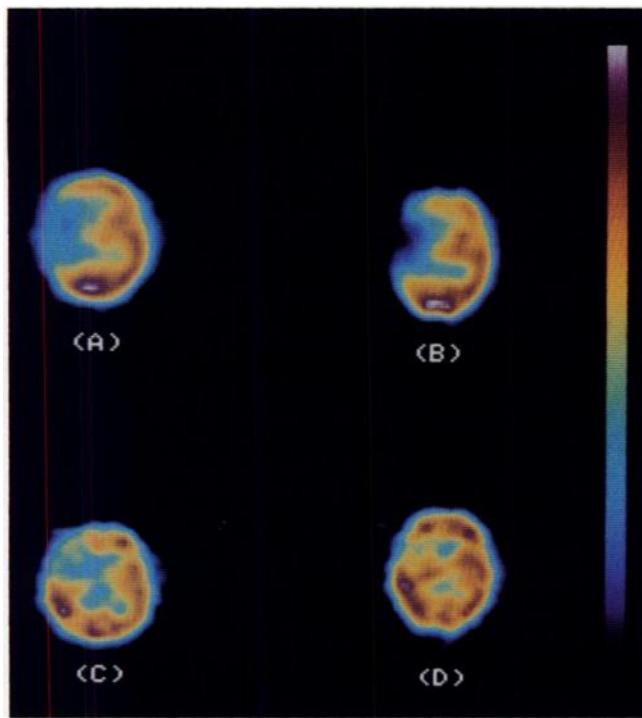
SPECT images obtained with ^{99m}Tc -ECD (top row) 60 min (A), 215 min (B) and with ^{123}I -IMP 25 min (C) and 185 min postinjection in a 71-yr-old female patient suffering from left hemiplegia and left lateral hemianopsia. It was a right middle cerebral artery stroke from cardiac origin. Early ECD 1 (A) displayed a large lesion with a differential hypoactivity versus normal parenchyma of $\sim 43\%$. Delayed ECD 2 (B) displayed a broader lesion with a higher differential activity of $\sim 64\%$. Early IMP 1 (C) showed a smaller sized lesion with a differential activity of $\sim 27.5\%$ and a delayed IMP 2 (D) with a incomplete redistribution ($\sim 17\%$). This image displayed a washin (redistribution) with IMP and a washout with ECD.
